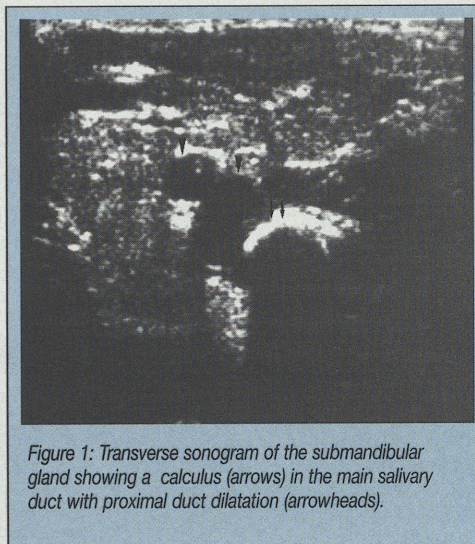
Transverse sonogram of the submandibular gland showing a calculus (arrows) in the main salivary duct with proximal duct dilatation (arrowheads).
